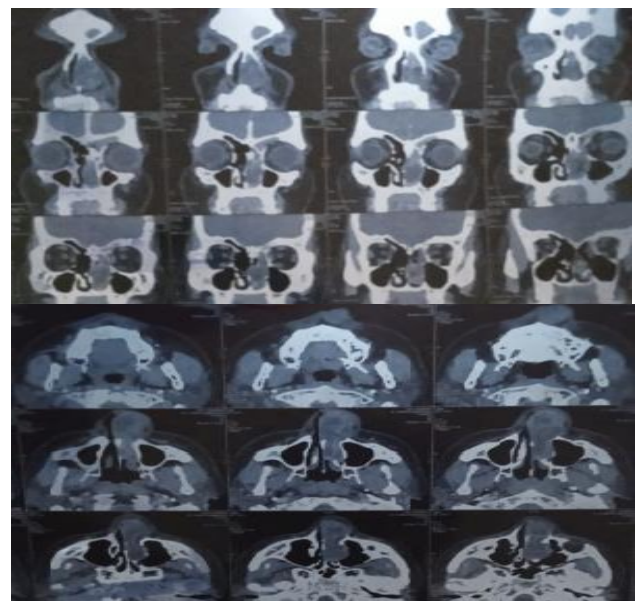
CT PNS- polypoidal heterogeneously enhancing soft tissue mass in left nasal cavity.
